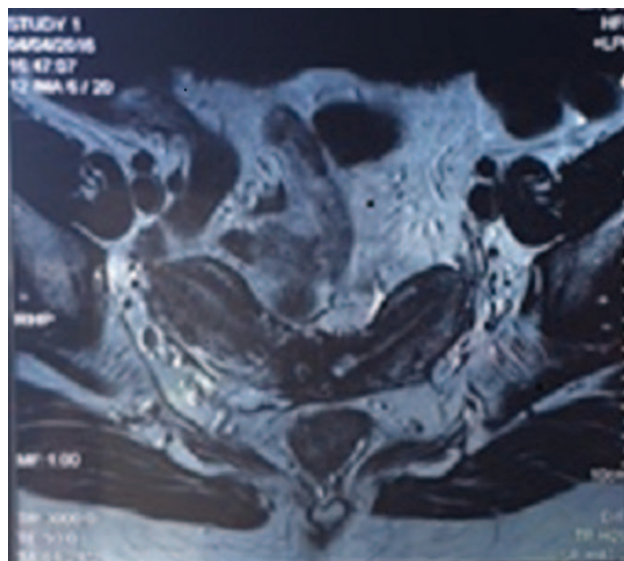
Magnetic resonance imaging (MRI) shows two separate uterus with two uterine cervix.
